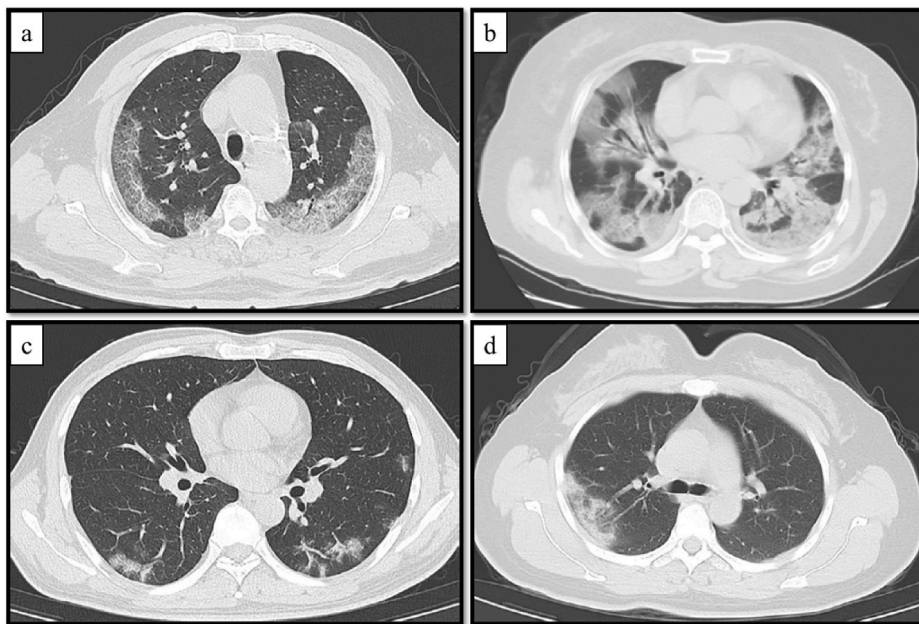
Axial CT images of positive COVID-19 patients (a) 74-year-old male patient suffering with cough for 5 days and evident for subpleural ground-glass opacities, (b) 55-year-old female patient has cough for 7 days, showing bilateral ground-glass opacities and consolidations (c) CT of 43-year-old male patient experience symptoms like cough and fever for one week showing peripheral ground-glass opacities and minimal consolidation and (d) 43-year-old female patient with cough for 5 days showing peripheral consolidation at the right lung region.
